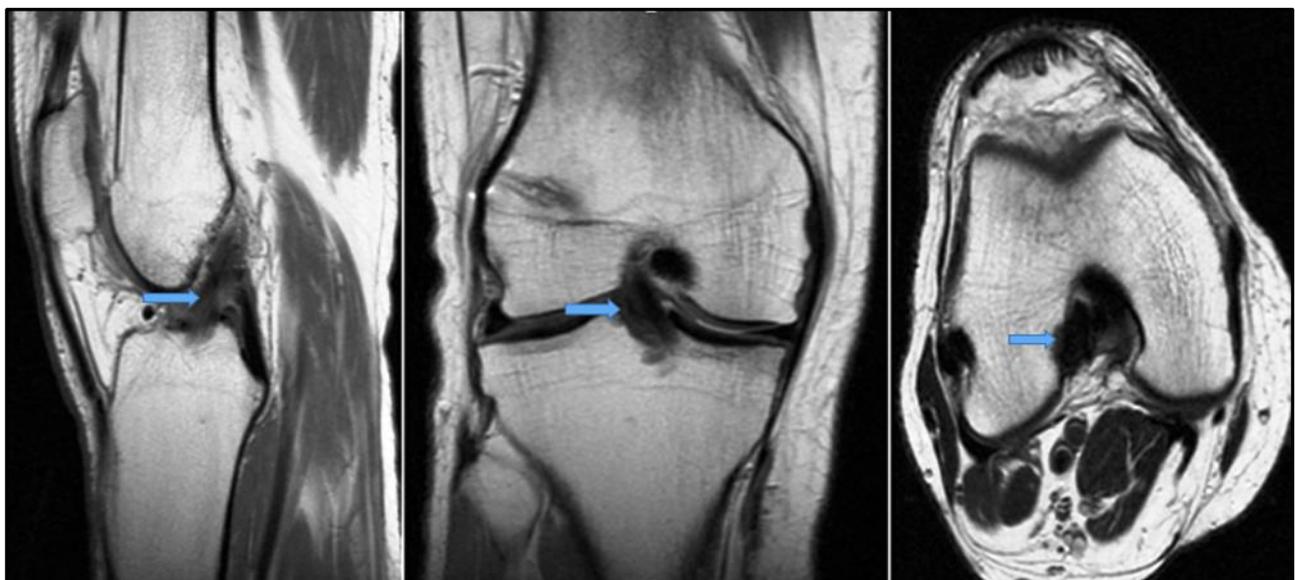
Sagittal intermediate-weighted, Coronal intermediate-weighted and axial T2-weighted MR Images, MR Image shows normal signal intensity within the ACL reconstruction graft(blue arrow).
